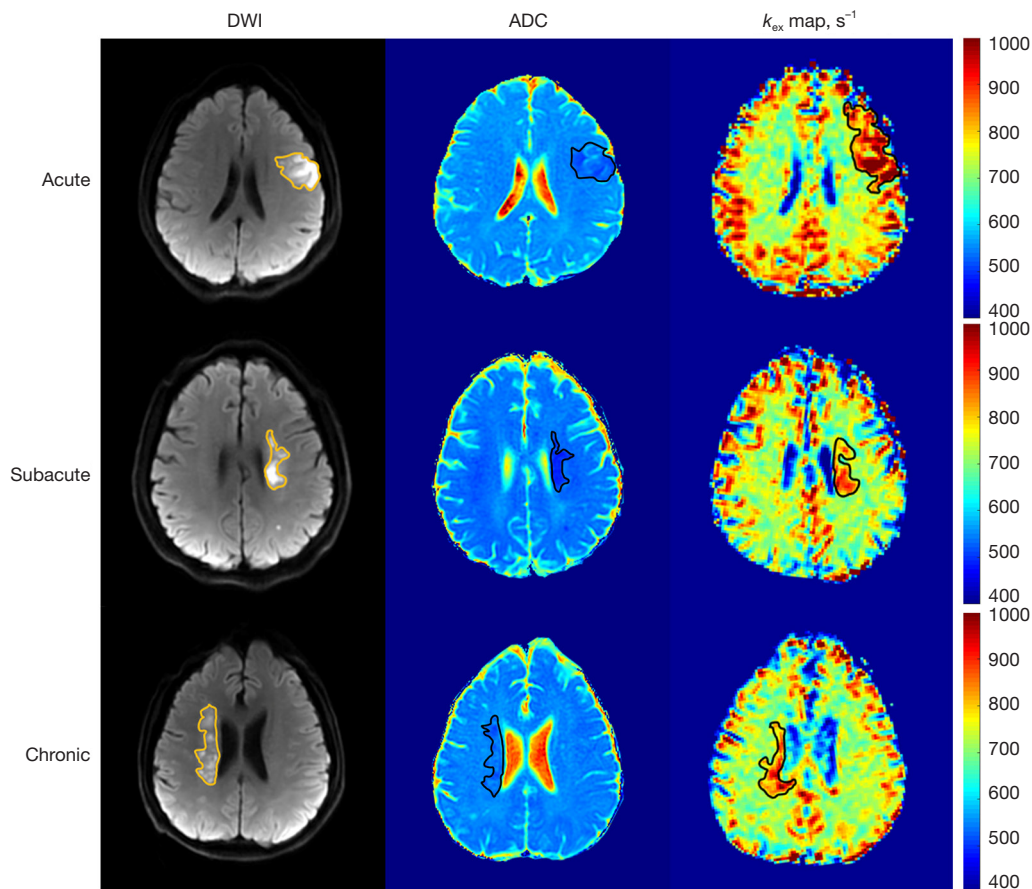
DWI, ADC maps, and k_{ex} maps of representative cases of acute, subacute, and chronic ischemic stroke phases. DWI, diffusion-weighted imaging; ADC, apparent diffusion coefficient; k_{ex} , proton exchange rate.
